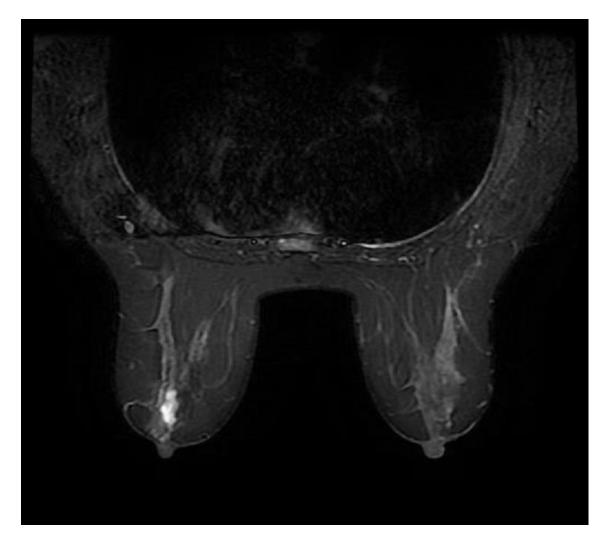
Left breast intraductal papilloma MRI (axial T2 fat sat) image of the same patient in Fig. 7 [155]
